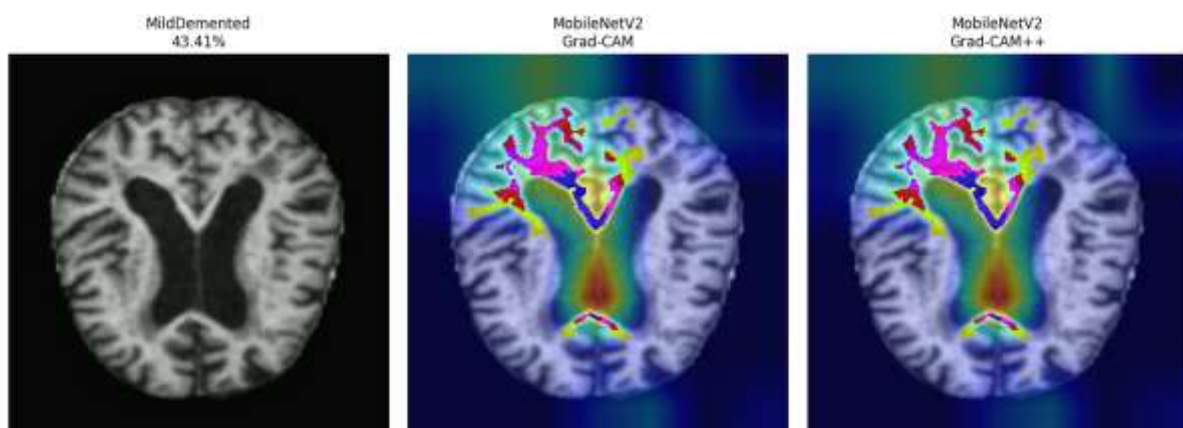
Grad-CAM and Grad-CAM++ visualization for an MRI slice classified as Mild Demented (43.41% confidence) using MobileNetV2.
